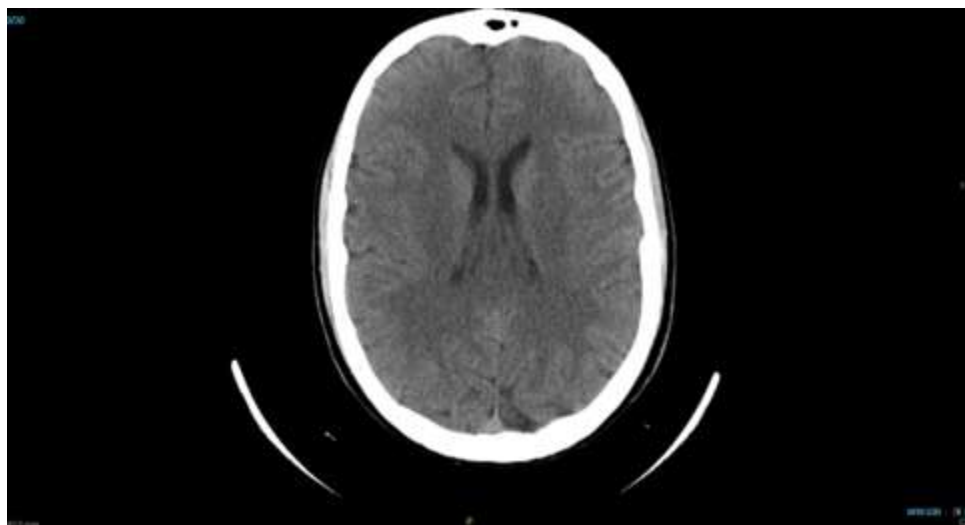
First CT brain on admission -Normal.
